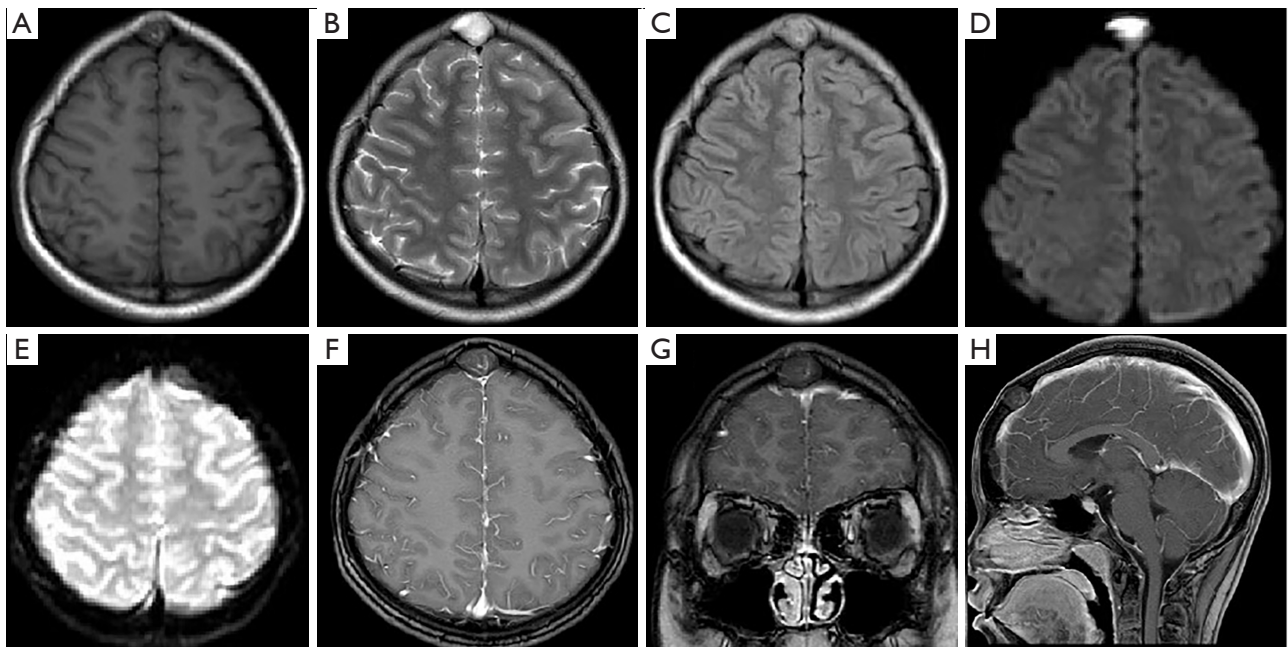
Brain MRI demonstrated a 2.0 cm × 1.6 cm × 1.4 cm mass in the midline area of the frontal skull. The tumor showed overall low signal with patchy high signal shadow in T1WI (A) and mixed high signal shadow in FLAIR (C). T2WI (B) and DWI (D) showed high signal shadow. The ADC (E) showed low signal. Axial (F), sagittal (G), and coronal (H) enhanced T1WI showed no significant enhancement, connecting with the adjacent meninges by a wide base and compressing the adjacent brain parenchyma. MRI, magnetic resonance imaging; T1WI, T1 weighted imaging; FLAIR, fluid-attenuated inversion recovery; T2WI, T2 weighted imaging; DWI, diffusion-weighted imaging; ADC, apparent diffusion coefficient.
